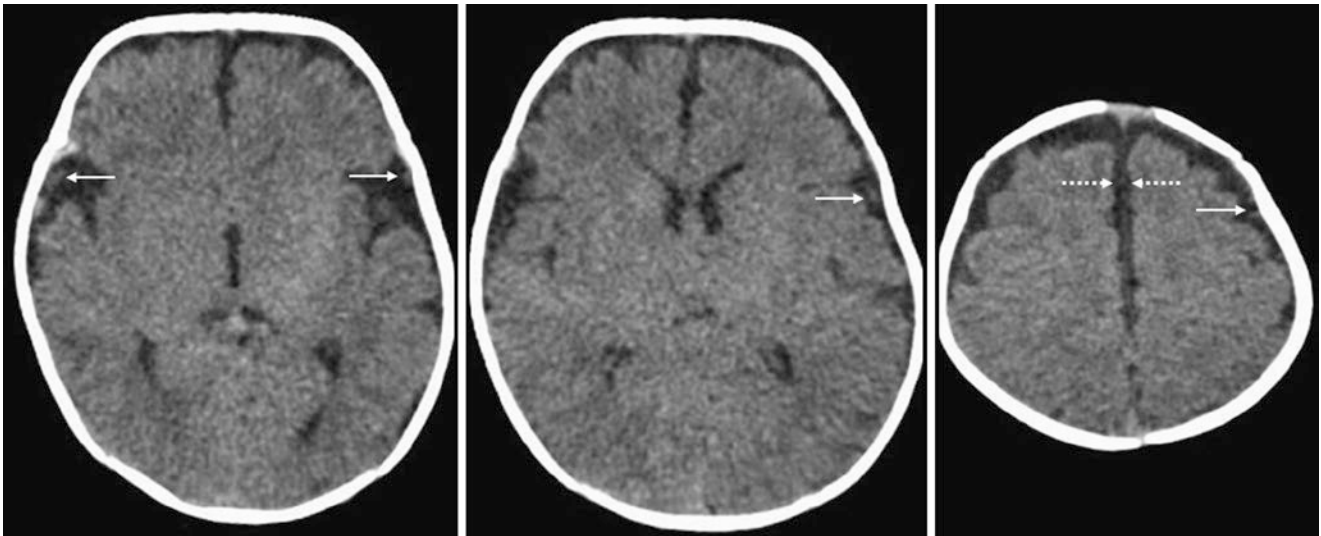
A 6-week-old evaluated for trauma had benign enlargement of the subarachnoid spaces of infancy (BESSI) on an otherwise negative NECT, with bilaterally enlarged subarachnoid spaces (SASs) within the sylvian fissures and along the frontal convexities. The interhemispheric fissures (*dotted arrows*) are also prominent. Note small cortical veins (*thin arrows*) traversing the SASs. A follow-up CT scan was not obtained
